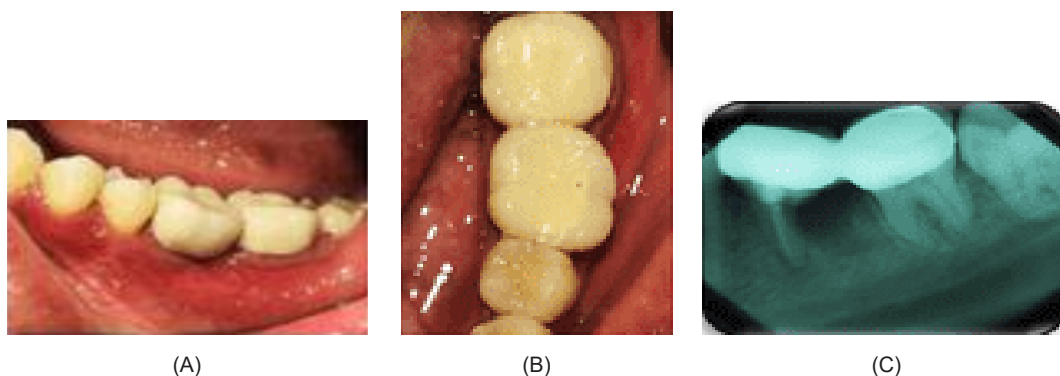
Clinical picture of PFM splinted crowns of teeth 36 and 37 during control, seen from (A) buccal and (B) occlusal; (C) Periapical radiograph during post-hemisection control. The post-extraction radiolucent image of the socket was smaller, it appeared that there was an ossification process.
